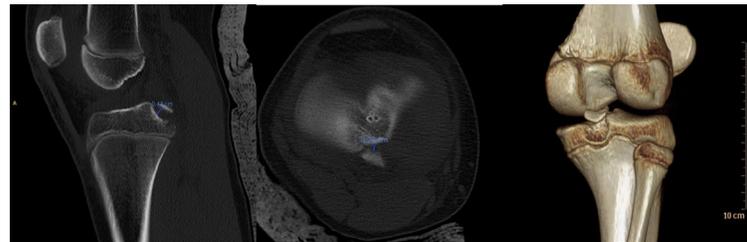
Computed tomography scan and 3D reconstruction of right knee.
